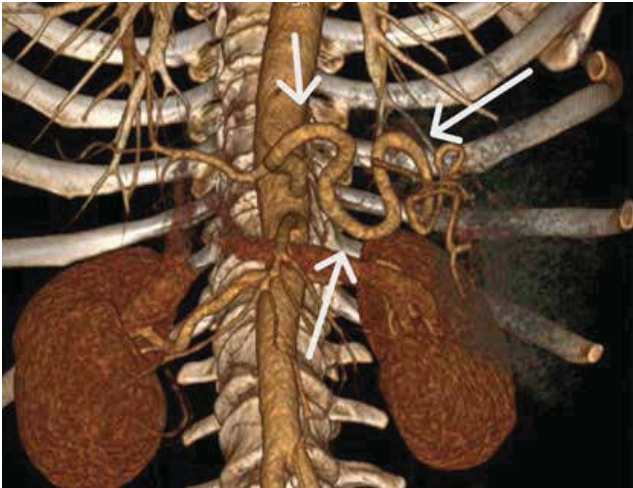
CT: tortuosity and significant dilation of the splenic artery (white arrows)
